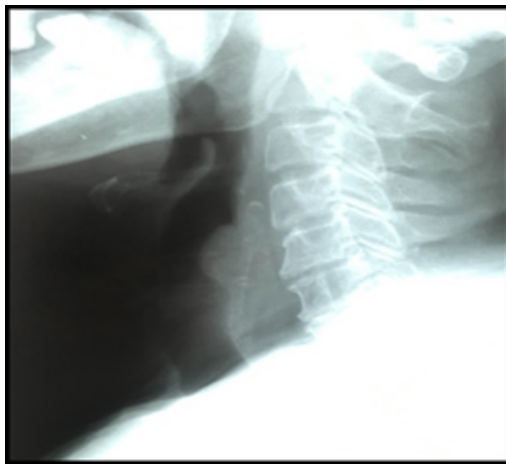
A linear radio opaque shadow seen at the level C5 on the lateral view of neck X-ray
